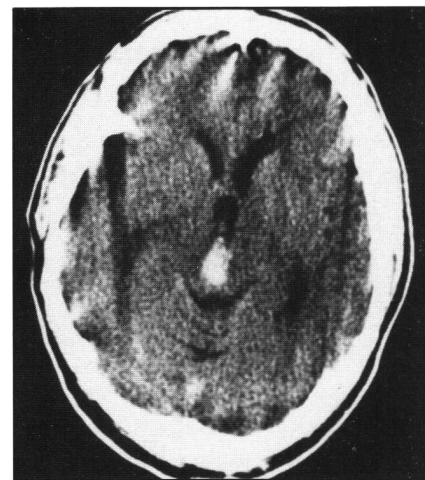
CT scan of patient 2 after placement of a right-sided ventriculostomy, showing significant reduction in ventricular size.
